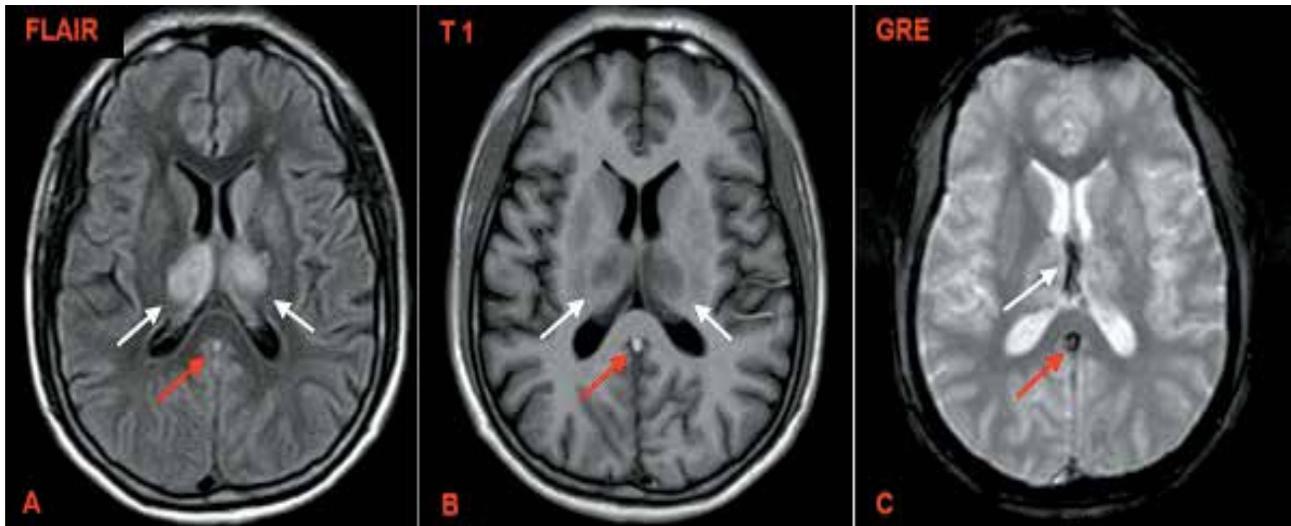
MRI of brain, axial FLAIR image, showing bithalamic infarct (white arrows).The high signal focus posterior to splenium of corpus callosum represents thrombosed vein of Galen (red arrow).
